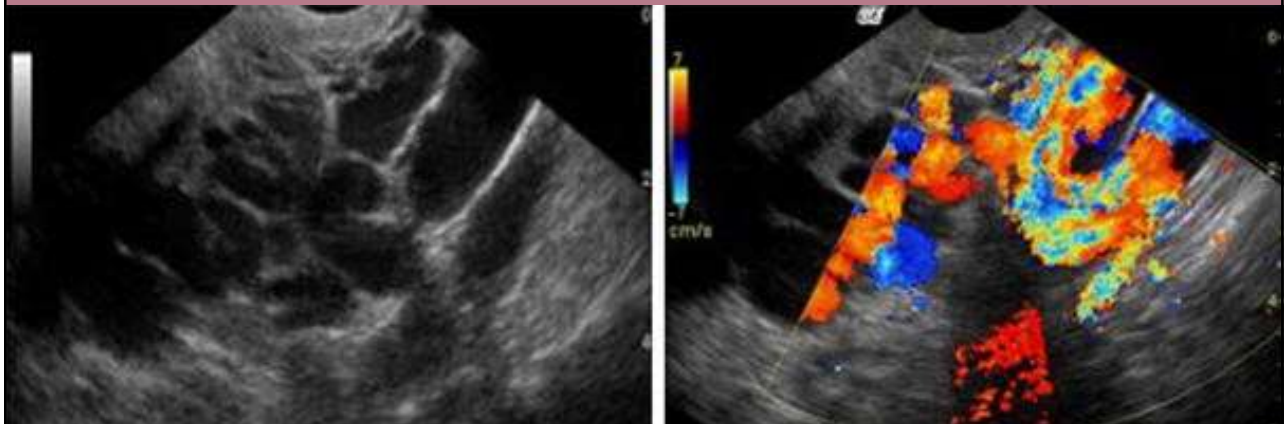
Transvaginal pelvic ultrasound image in axial section of a 33-year-old woman with the use of B-mode (a) and color-Doppler (b) demonstrates marked engorgement of veins surrounding the left ovary vein.<sup>24</sup>
